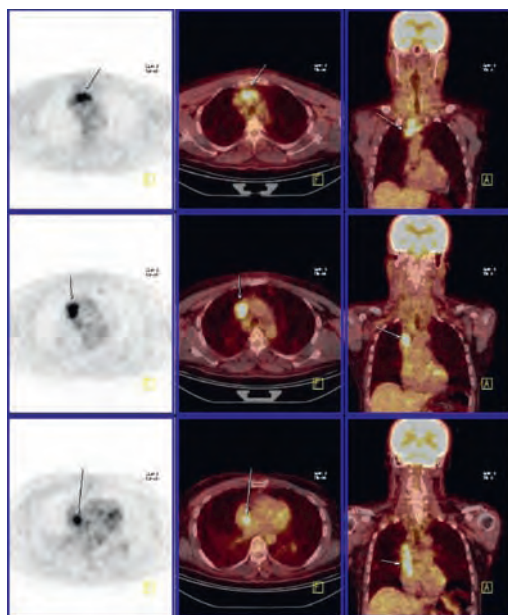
PET-CT study shows increased ^{18}F -FDG uptake at the LBCV (upper row), the SVC (middle row) and the RA (lower row).
